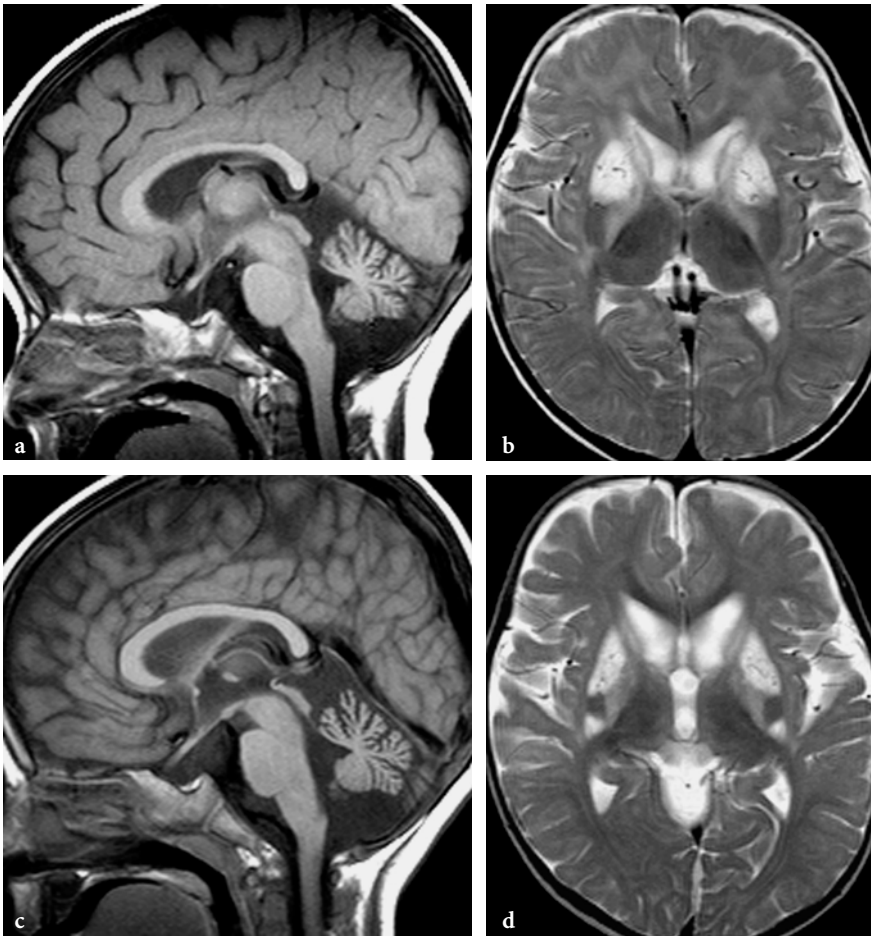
MR imaging studies in a male patient with 3-methylglutaconic aciduria (with hypermethioninemia). a Sagittal T1-weighted spin echo image at the age of 1 year, showing marked cerebellar atrophy. b Axial T2-weighted fast spin-echo image at the same age. Bilateral basal ganglia disease. The globi pallidi and the heads of the caudate nuclei show moderate hypersignal and atrophy already (burned-out disease). The anterior parts of the putamina are swollen (the small punctuate signal voids are most probably enlarged vessels) and markedly hyperintense, whereas the posterior parts of the putamina appear to be normal. c Sagittal T1-weighted spin-echo image at the age of 2 years. Subtle, but clear interval progression of cerebellar atrophy. d Axial T2-weighted fast spin-echo image at the same age. The basal ganglia changes also show progression. The anterior parts of the putamina are less swollen, but the posterior parts are abnormal and the intermediate zone is still apparently normal. Mild diffuse brain atrophy and delayed myelination
